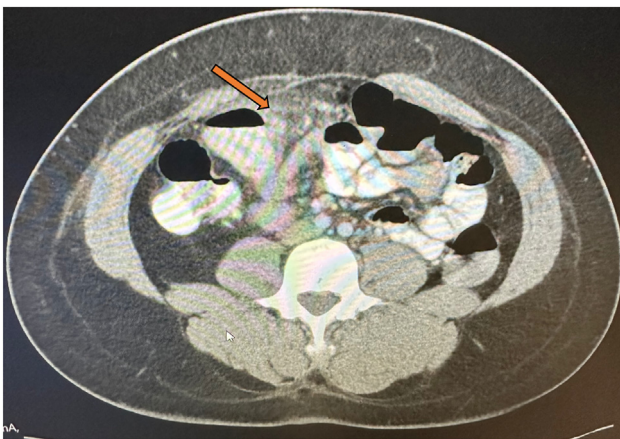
CT scan of the abdomen is showing decrease inflammatory changes involving a portion of the proximal to mid-transverse colon (orange arrow).
